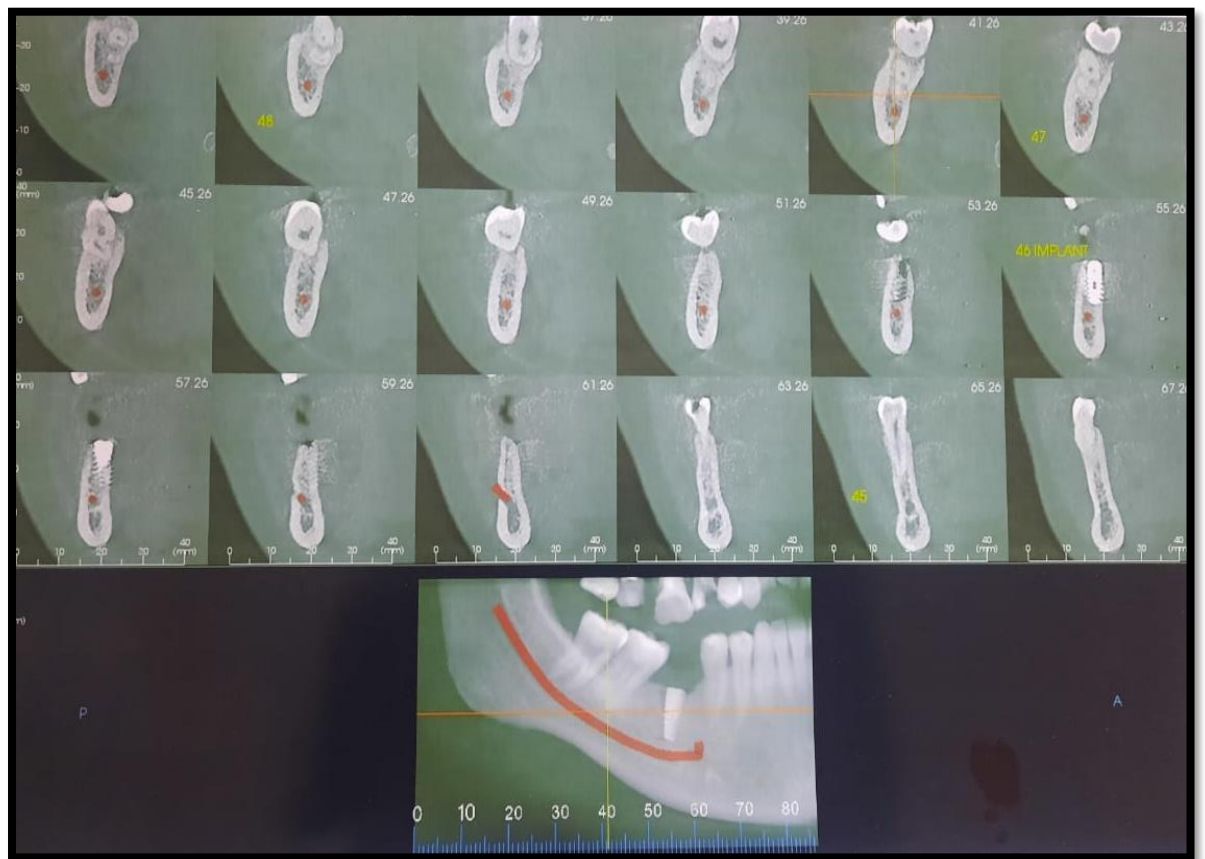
Post Op CBCT in coronal view
